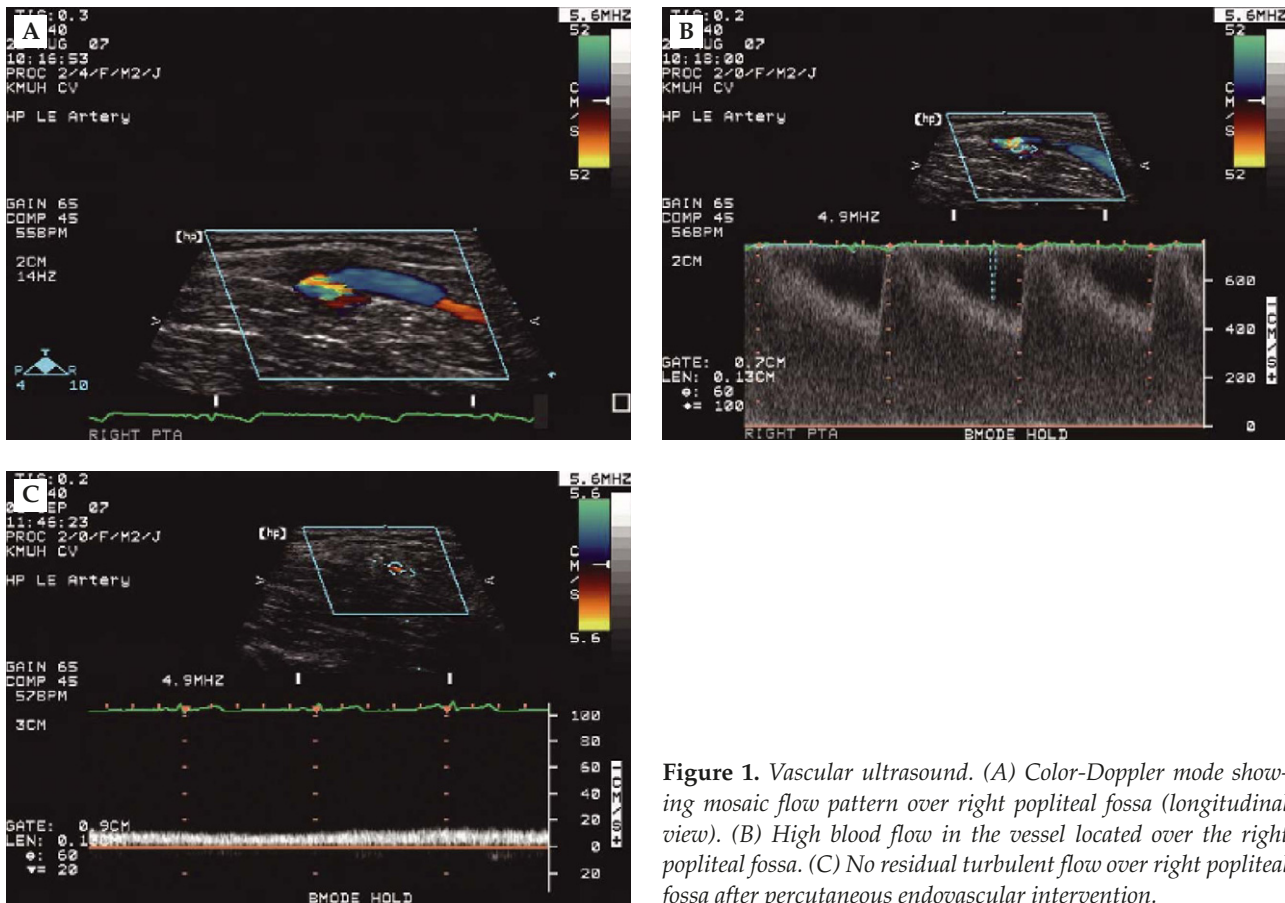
Vascular ultrasound. (A) Color-Doppler mode showing mosaic flow pattern over right popliteal fossa (longitudinal view). (B) High blood flow in the vessel located over the right popliteal fossa. (C) No residual turbulent flow over right popliteal fossa after percutaneous endovascular intervention.
